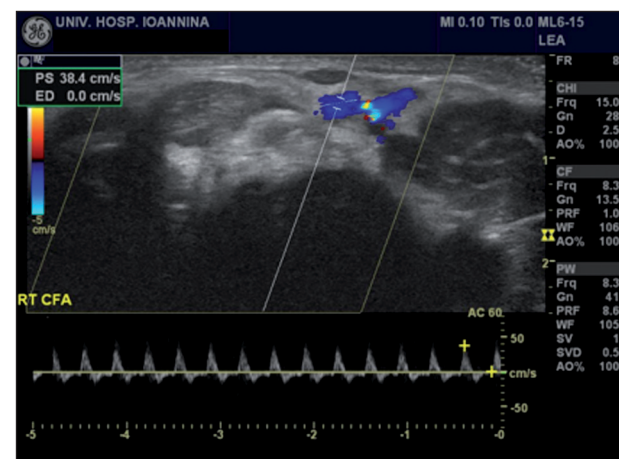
Sonographic confirmation of restored right common femoral artery (CFA) patency.
